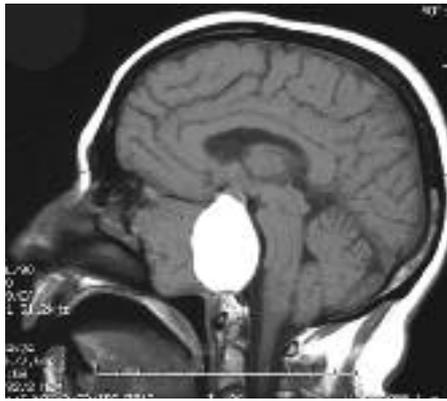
MRI: Pre-contrast (a) large mass with iso- and hyperintense components compressing the pons. Post-contrast (b) enhancement of the initially isointense portion of this sphenopetroclival mass
